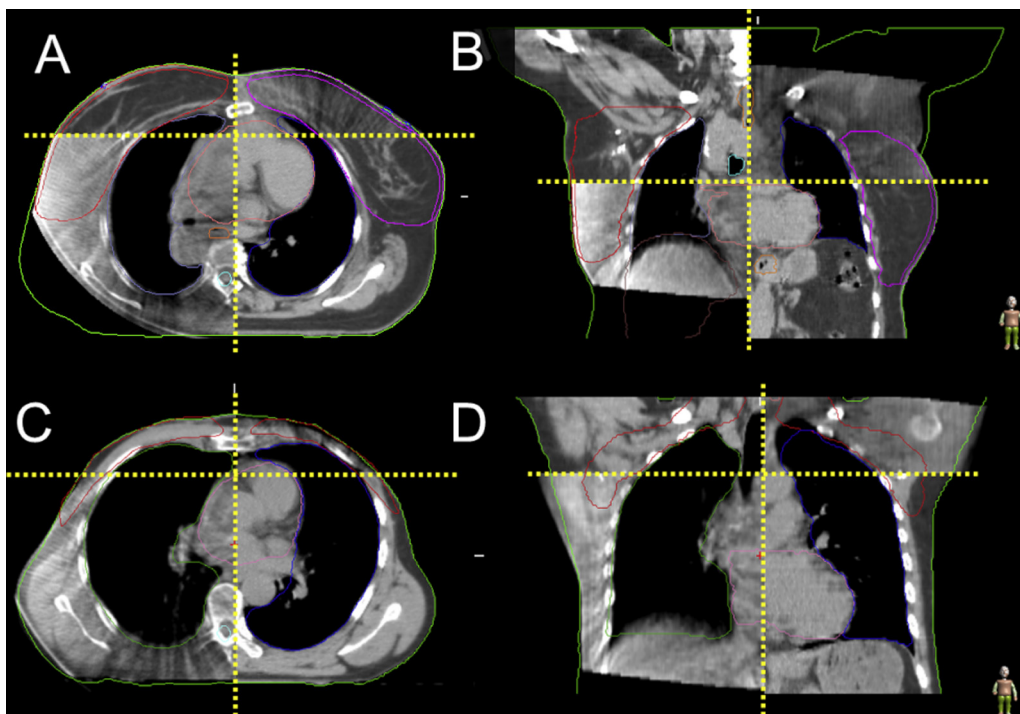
Patients were imaged with a daily CBCT. An example of the quartered 3D-matching (dose planning CT and CBCT) is given for Pat#1 and Pat#2 for axial (A, C) and coronal (B, D) directions, respectively.
